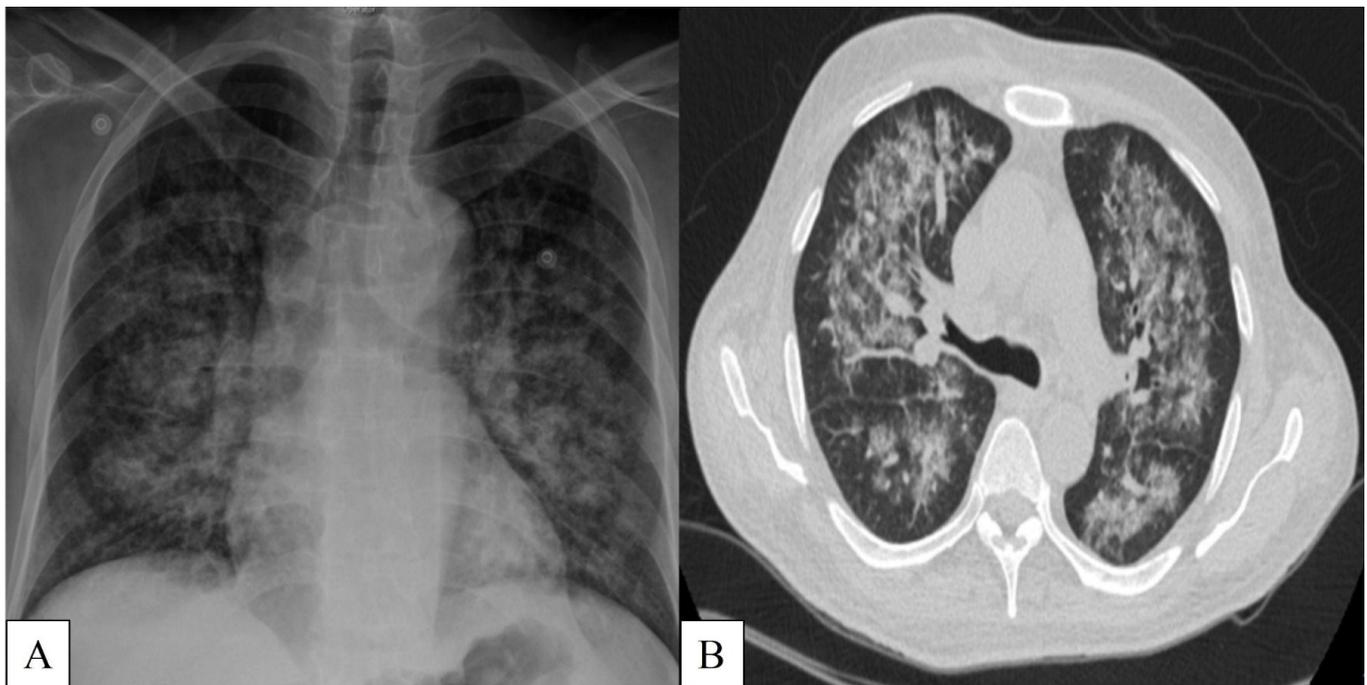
Pulmonary imaging (A: Chest X ray, B: Computed Tomography Scan) of the patient with pyrethroid poisoning
